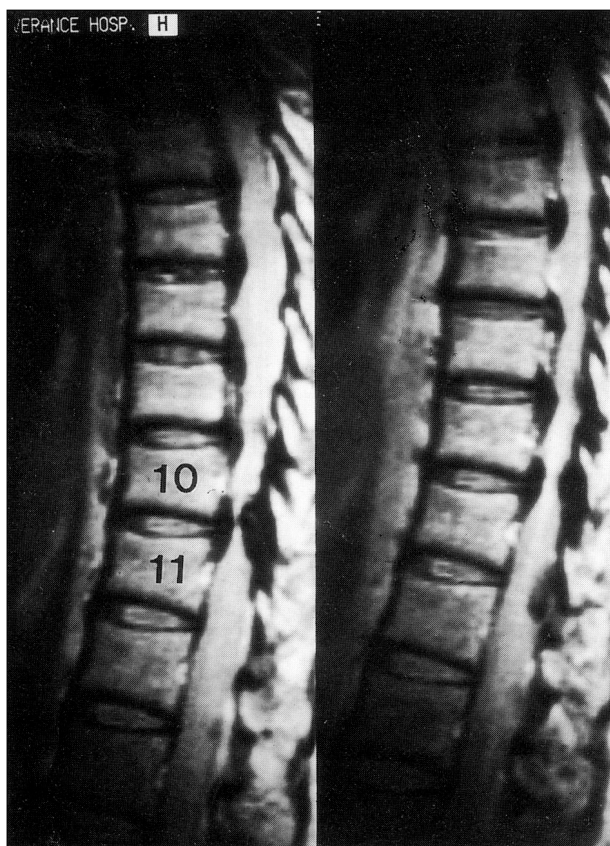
T2-weighted sagittal MR image showing posterior indentation of the spinal cord and anterior compression of the cord at the level of T10-11.
